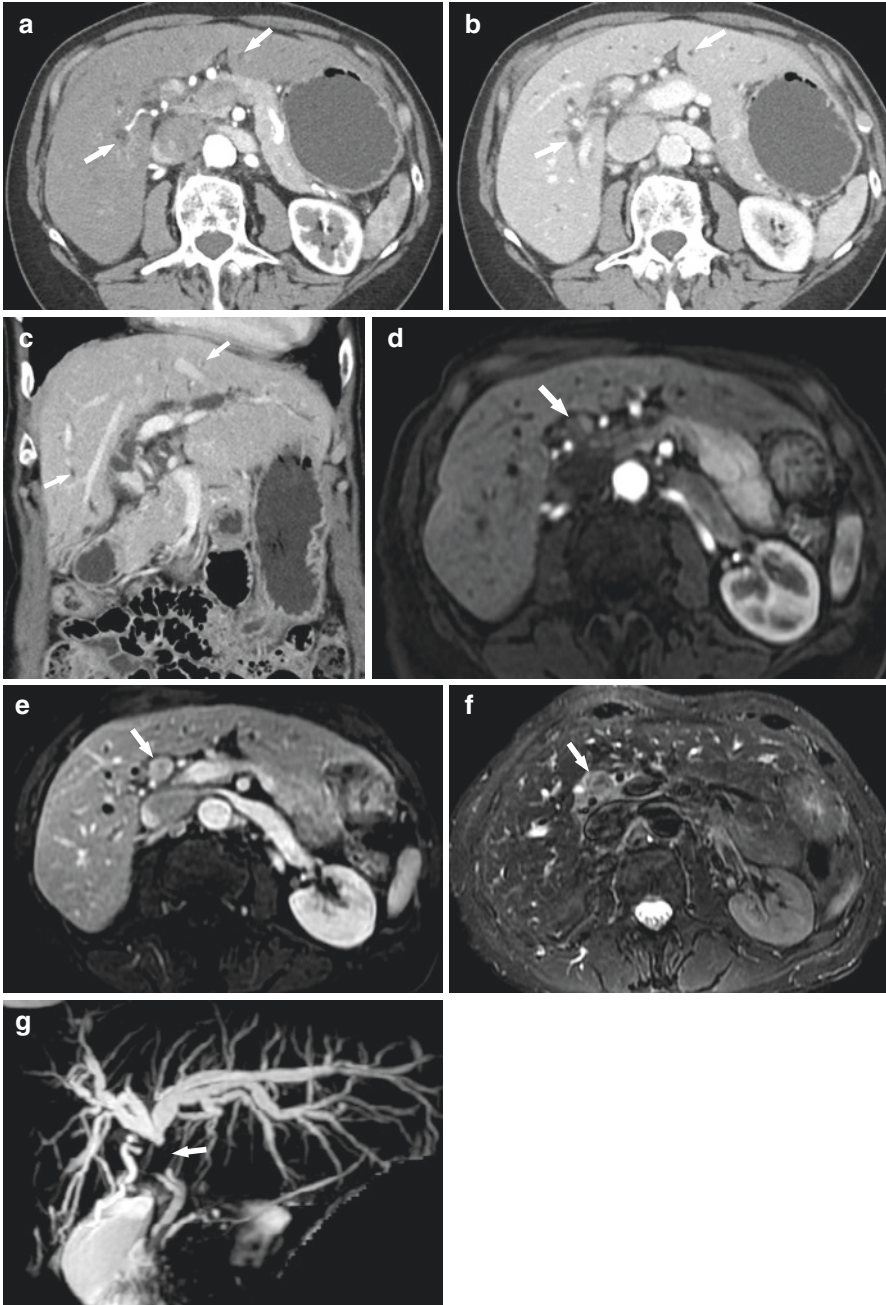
Periductal-infiltrating cholangiocarcinoma (Klatskin tumor). Axial CT in arterial phase (a), portal venous phase (b), and coronal reconstruction (c) demonstrate dilatation of the biliary tree in both liver lobes (arrows). T1-weighted MR images show small heterogeneously enhancing lesion (arrow) adjacent to the hepatic hilum with progressive enhancement during arterial phase (d) and portal venous phase (e) T2-weighted sequence (f) shows centrally hypointense signal (arrow). MRCP (g) demonstrates significant dilatation of the biliary system in both liver lobes with abrupt cut-off in the hepatic hilum at the level of tumor (arrow)
